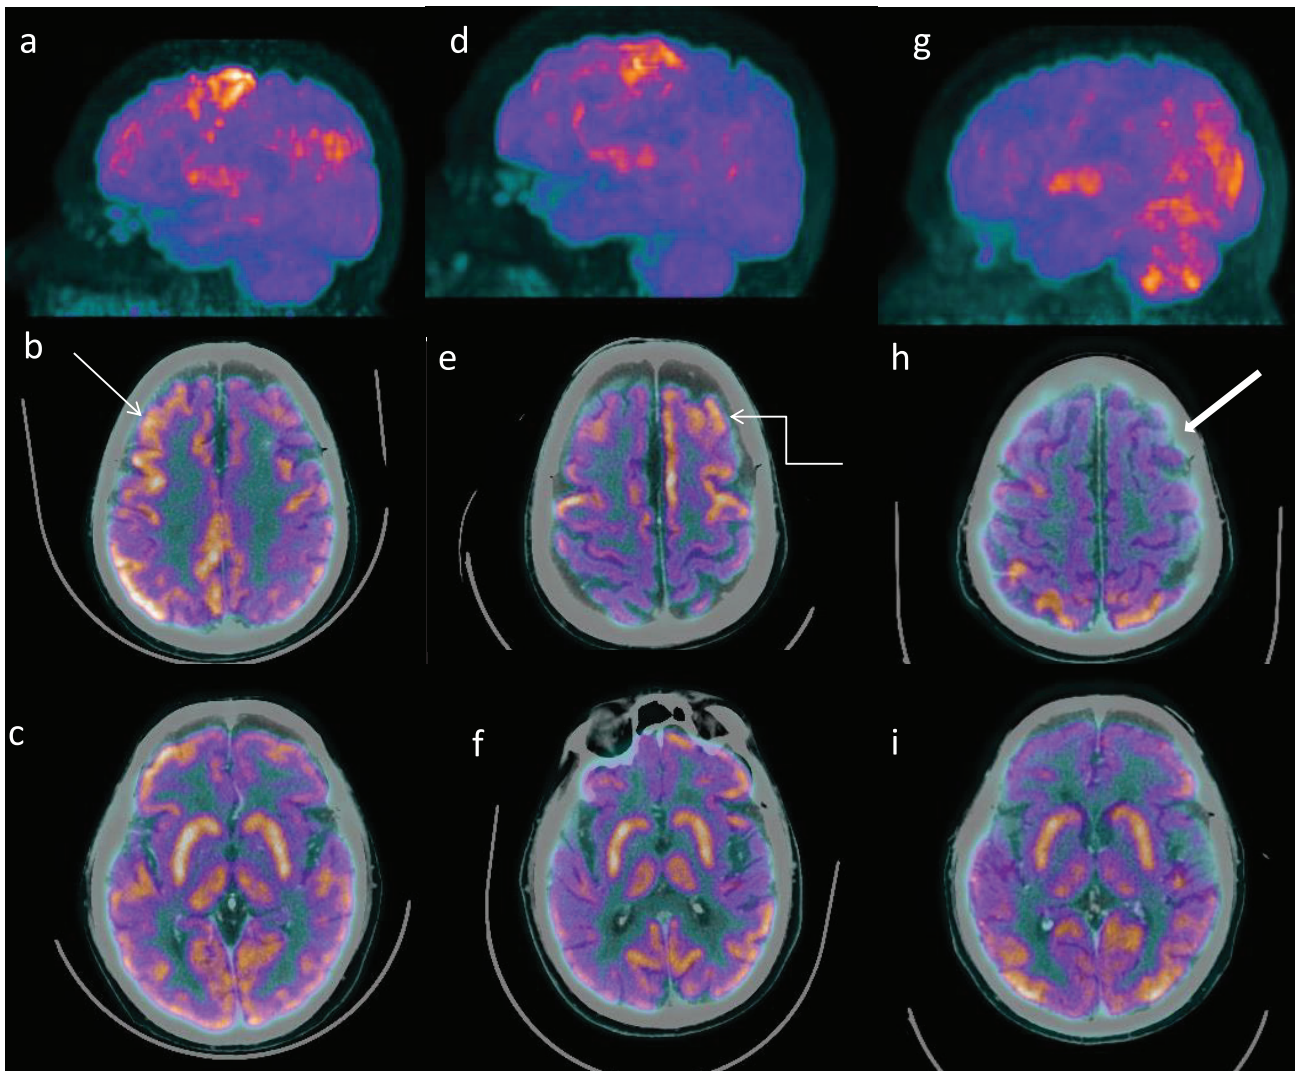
Shows MIP and fused axial PET/CT images of three sequential FDG PET CT done on 22/7/22, 16/3/24 and 10/4/24 in a 77-year-old patient presenting with recurrent complex partial seizure. PET CT done on 22nd July 22 (a-c) showed heterogeneous increased metabolic uptake in right fronto-parietal cortex (white arrow), left high frontal cortex (not shown in image). Follow up PET/CT done on 16/3/24 (d-f) showed (curved arrow), mildly in right frontal lobe. Follow up PET/CT done on 10/4/24 (g-i) showed resolution of previously seen heterogeneously increased FDG uptake in bilateral frontal lobes. Bilateral frontal and temporal lobes show reduced FDG uptake (thick white arrow) relative to heterogeneously increased FDG uptake in bilateral parieto-occipital cortices and heterogeneously increased FDG uptake noted in left frontal lobe cerebellum.
